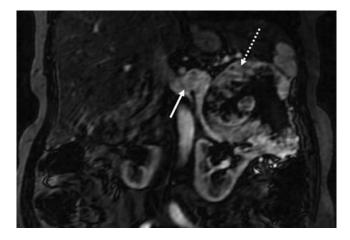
Preoperative abdominal MRI that demonstrates an 11-cm upper pole mass (dashed arrow) in the left moiety of a horseshoe kidney with a left renal vein thrombus (straight arrow) extending to the confluence of the inferior vena cava.
